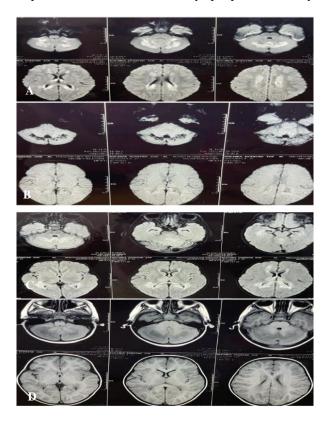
(A-D): Bilaterally symmetrical multifocal lesions of cytotoxic edema, restricted diffusion on DWI, hyperintense on FLAIR, mildly hypointense on T1W images are seen in bilateral cerebellar white matter, anterior thalami, corpus callosum, and bilateral deep corona radiata. Multiple punctuate foci of blooming on SW images are seen in the lesions of bilateral cerebellar white matter and the posterior body of the corpus callosum represents hemorrhagic foci.
